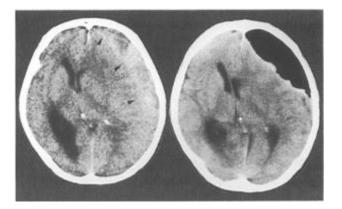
shows two CT scans side by side. On the left is the preoperative scan, and on the right is the postoperative scan. This case is an example of a unilateral convexity type. You can see that the hematoma (marked by arrowheads) has been completely replaced with oxygen in the postoperative scan. There's no sign of oxygen in the spaces around the brain, like the subarachnoid spaces or the subdural spaces beyond the hematoma cavity.
